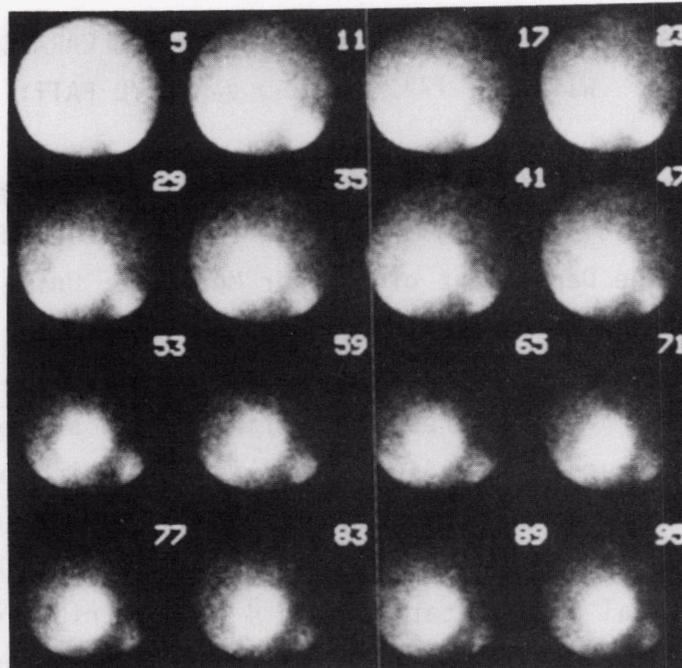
Serial scintigrams after i.v. injection of 3 mCi $[^{123}\text{I}]\text{BMIPP}$ in a patient with normal coronary arteries. Each image represents the sum of five 1 min frames. (Courtesy, R. Dudczak, M.D., University of Vienna, Austria).
